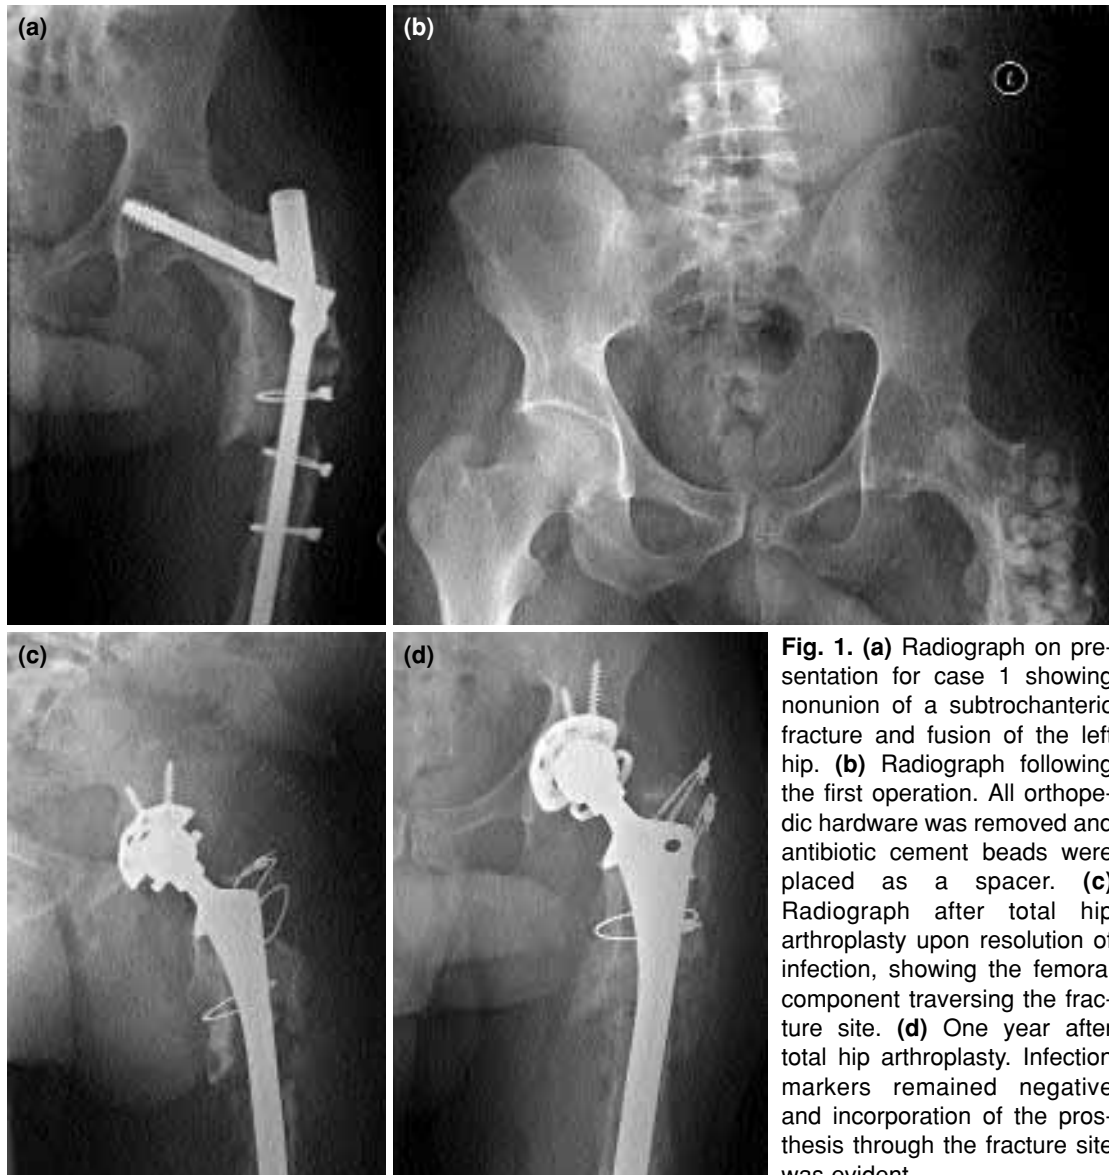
(a) Radiograph on presentation for case 1 showing nonunion of a subtrochanteric fracture and fusion of the left hip. (b) Radiograph following the first operation. All orthopedic hardware was removed and antibiotic cement beads were placed as a spacer. (c) Radiograph after total hip arthroplasty upon resolution of infection, showing the femoral component traversing the fracture site. (d) One year after total hip arthroplasty. Infection markers remained negative and incorporation of the prosthesis through the fracture site was evident.
